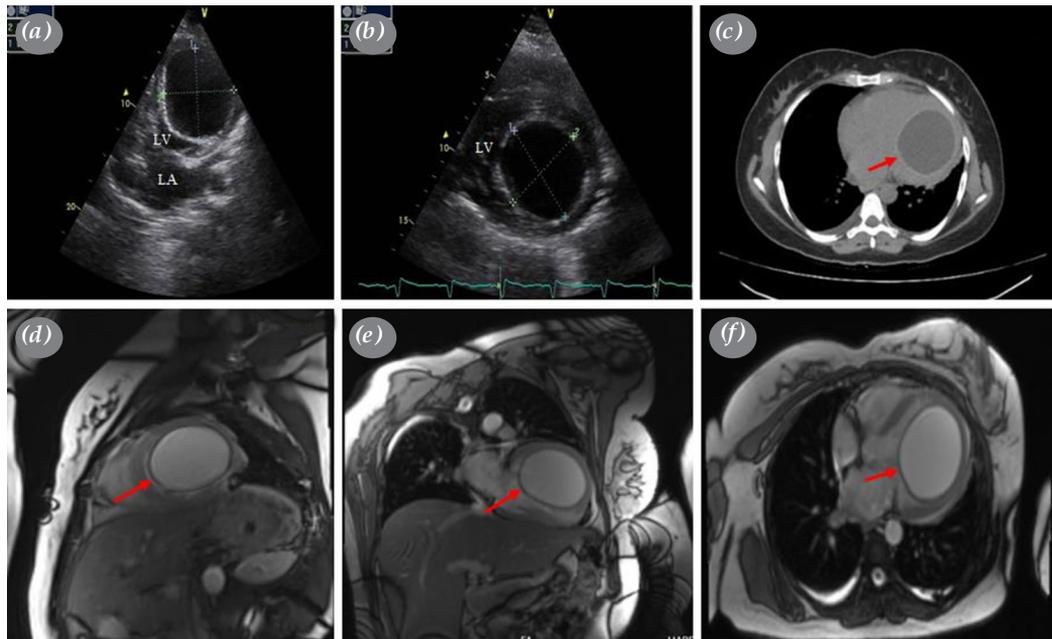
(a) Apical four-chamber view on transthoracic echocardiography, longitudinal section of the cyst. (b) Transverse section of cyst in parasternal short axis view on transthoracic echocardiography. (c) Hypodense cyst appearance in the left ventricle on computerized tomography (red arrow). (d) Hyperintense cystic lesion in the left ventricular cavity in the sagittal T2-weighted section (red arrow). (e) Hyperintense cystic lesion in the left ventricular cavity in the coronal T2-weighted section (red arrow). (f) Hyperintense cystic lesion in the left ventricular cavity in the axial T2-weighted section (red arrow).
